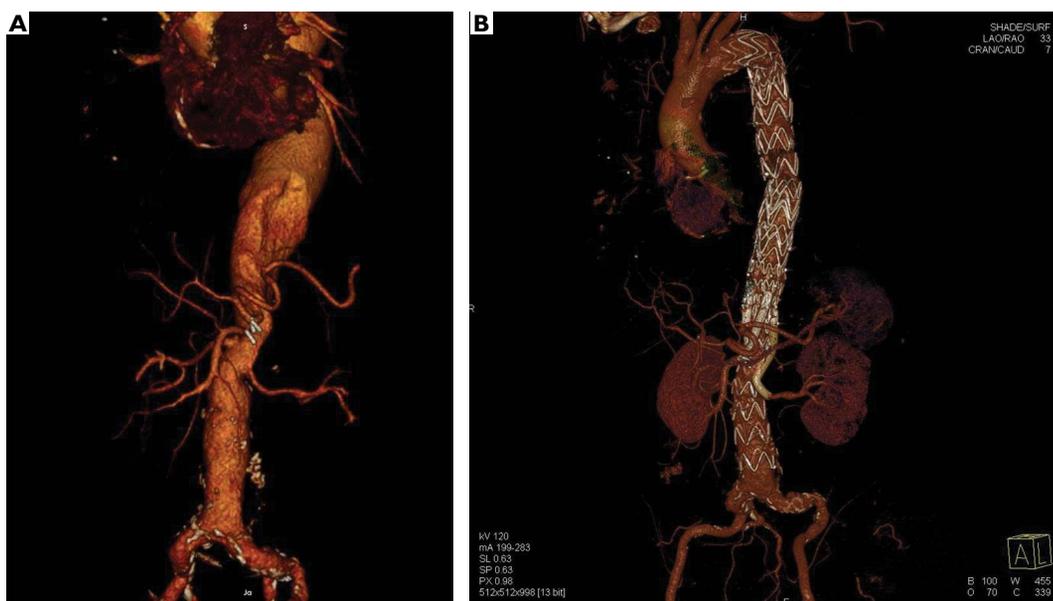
Patient 26. A volume rendering CT reconstruction shows proximal paraanastomotic and suprarenal aneurysm (A). A volume rendering CT performed 12 months after implantation of branched Colt stent-graft (B)
